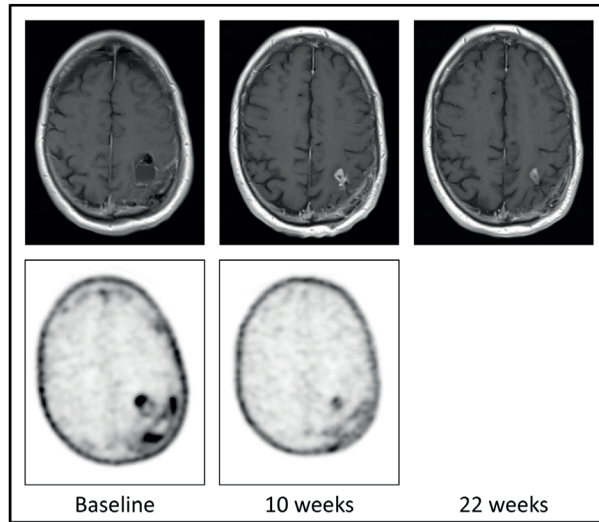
FLT-PET images at baseline (left) and 10 weeks (right) and MRI images at baseline (left), 10 weeks (middle) and 22 weeks (right) of a patient with pseudoprogession. SUV_{max} on baseline FLT-PET was 1.44, SUV_{max} at 10 weeks 0.74.
